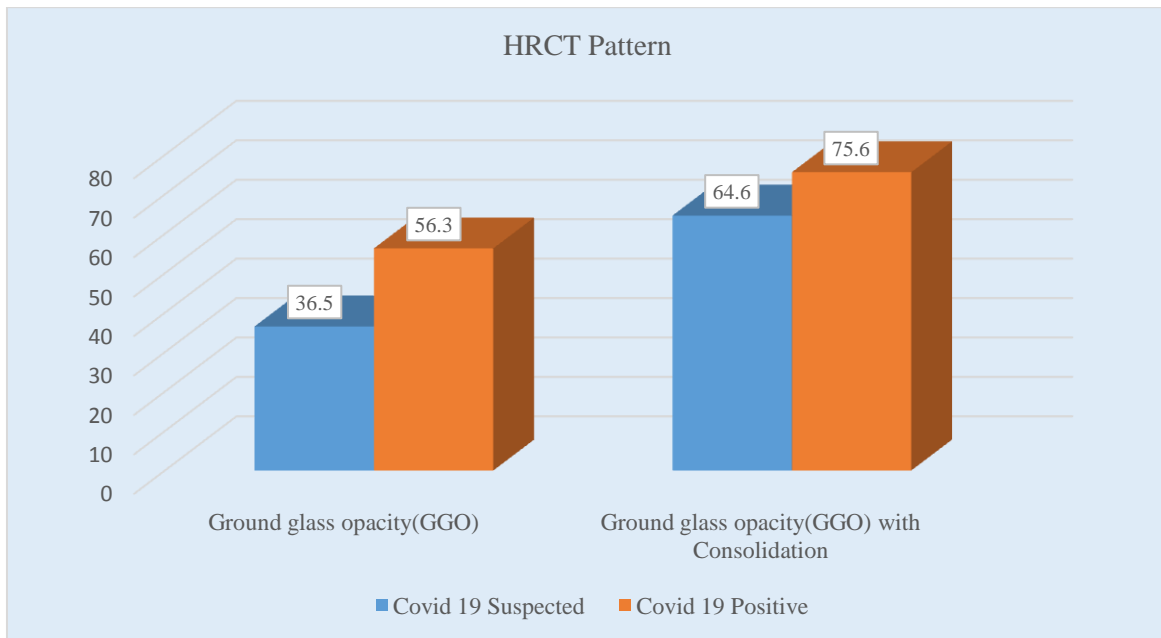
Comparative HRCT Pattern between the participants (N=126)
